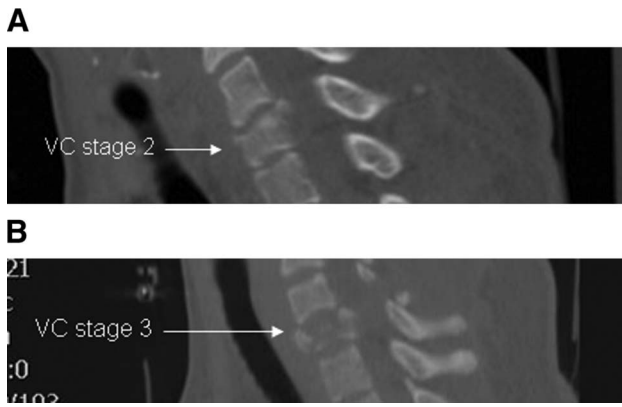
Reformatted sagittal computed tomography views of cervical spine indicating vertical compression (VC) fracture stages 2 and 3 of Allen et al Classification. In VC stage 2 (A) there is cupping of superior and inferior end plates of C6 vertebral body and in VC stage 3 (B) there is significant compression fracture of the vertebral body with protrusion of bone fragments into the spinal canal. The latter is an example of a burst fracture.
